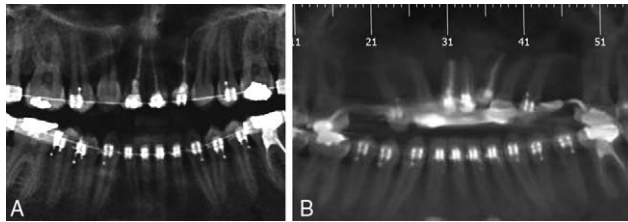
(A) Panoramic x-ray before surgery. (B) Panoramic x-Ray after 14 mm of distraction.
